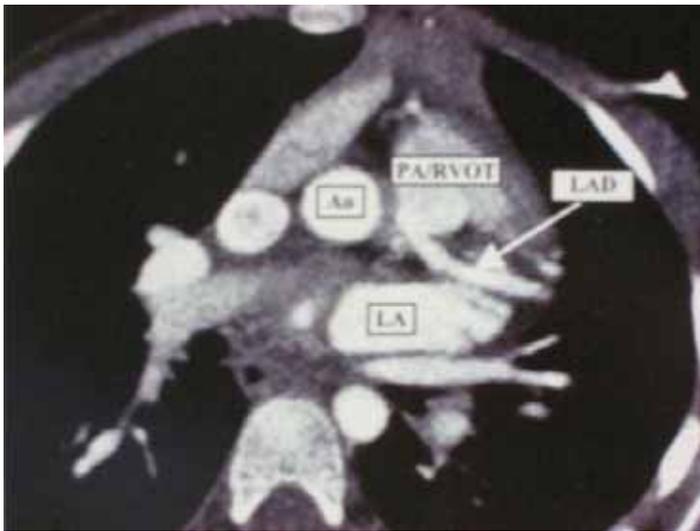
A cardiac CT angiography depicting patient's left main coronary anomalously originating from the pulmonary artery / right ventricular outflow tract.
